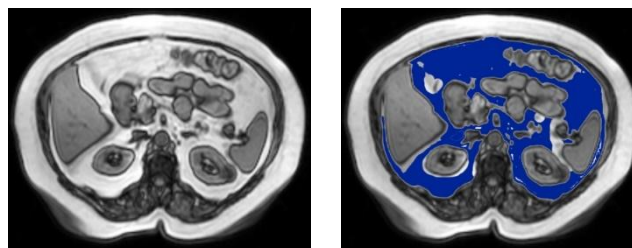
(a): Abdominal MRI of an Individual with Obesity
